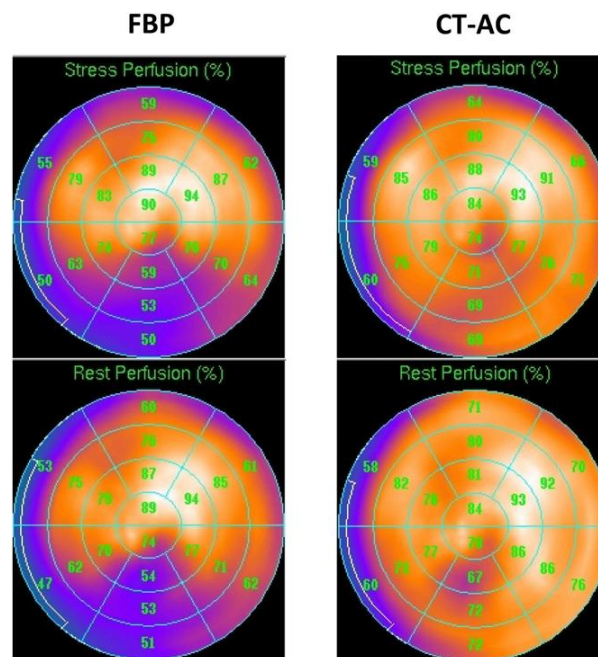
shows the example of a polar map with Filter Back Projection (FBP) and CT Attenuation Correction (CT-AC)
